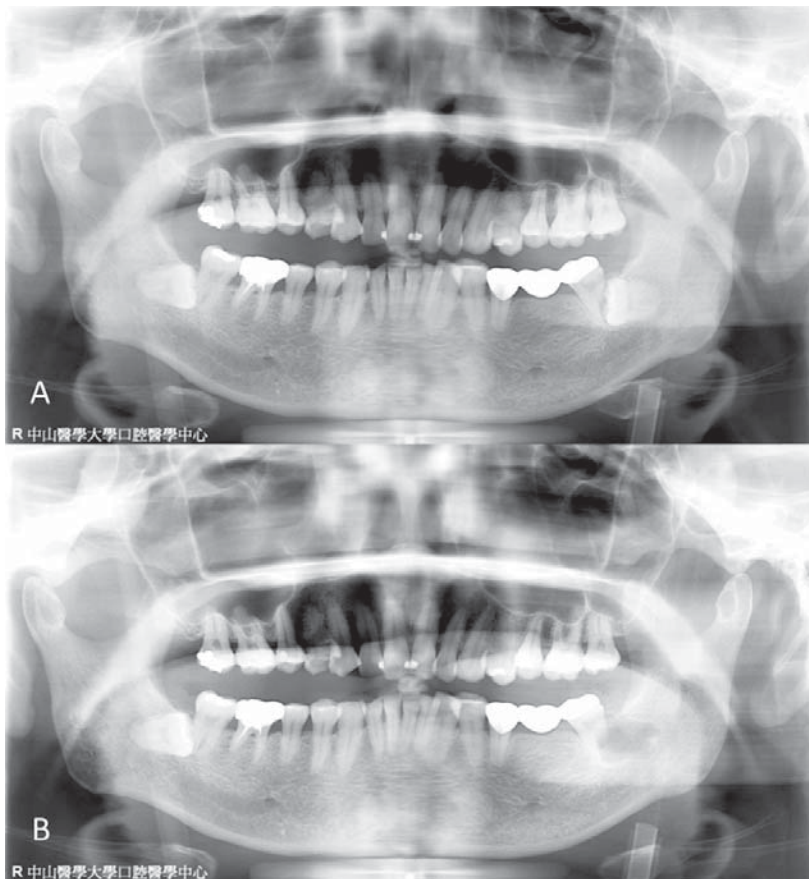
These panoramic radiography images were obtained on the same day just before (A) and after (B) tooth extraction. Distal root resorption of the tooth 37 is noted.
